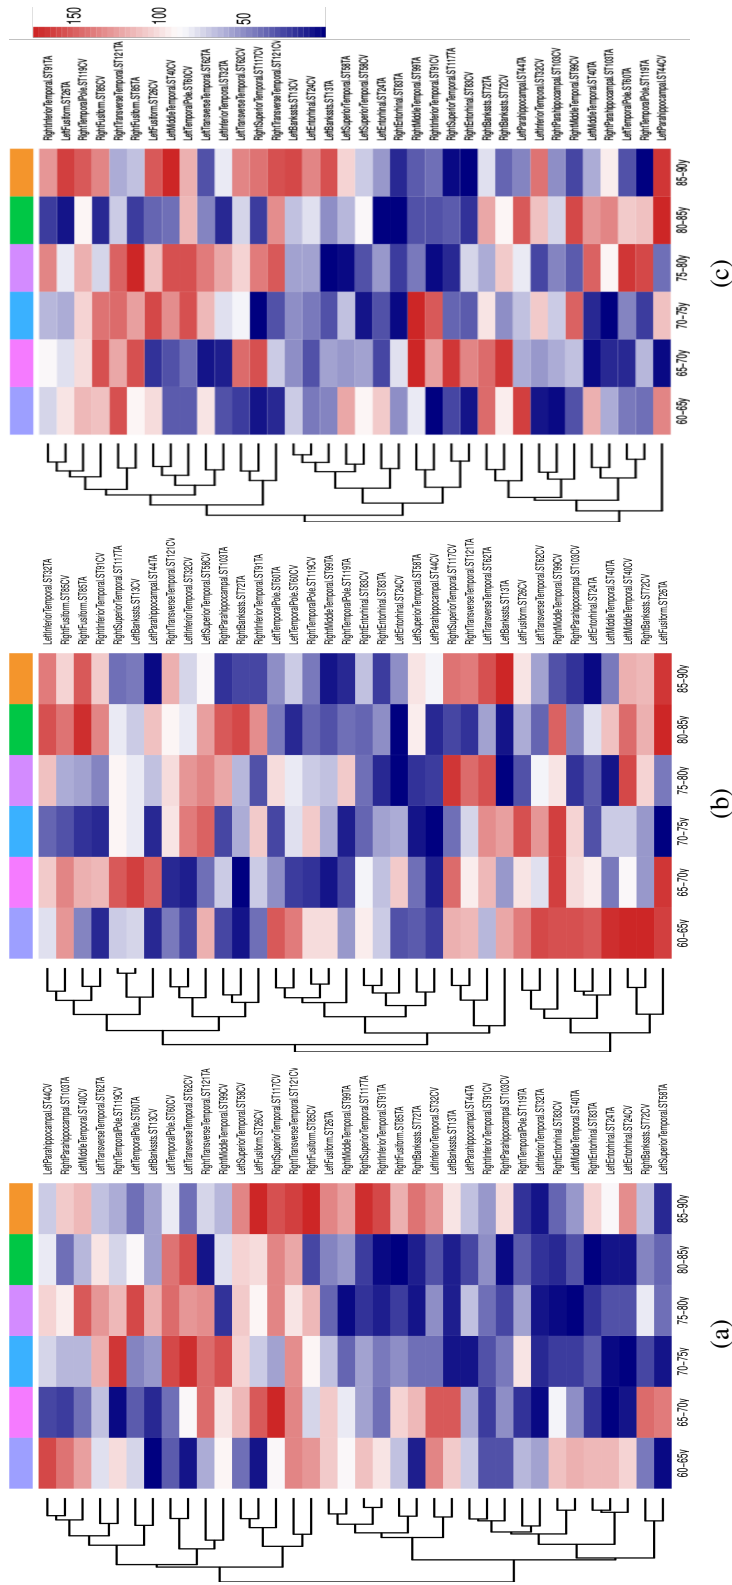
mRMR ranking achieved by the MRI biomarkers of the temporal lobe. (a) AD vs HC. (b) MCI vs HC. (c) AD vs MCI. Red colours mean that features were in the lowest ranking positions; blue colours that the features ranked in the first positions.
